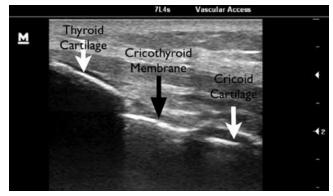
Longitudinal ultrasound view of the cricothyroid membrane. (Source www.aucklandems.com/2012/12/05/ultrasound-assistedsurgry-airway)
